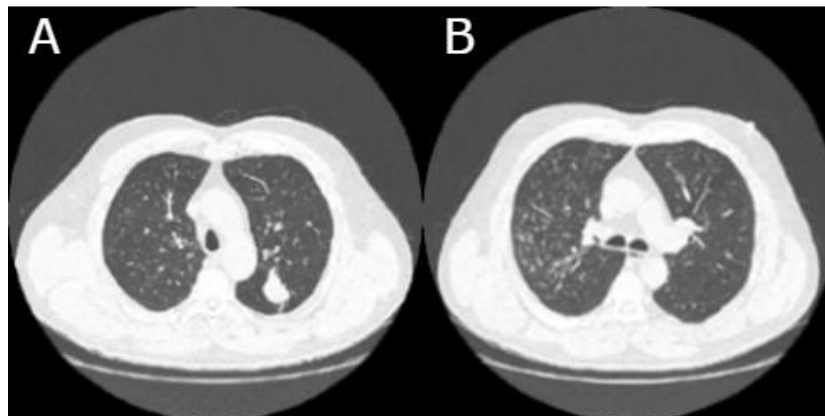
Computed tomography of lung (02/2019): A – tumor of upper lobe of left lung measuring 35 × 44 × 24 mm; B – fine nodule lesions of budding tree type and infiltrative-atelectasis densities.
